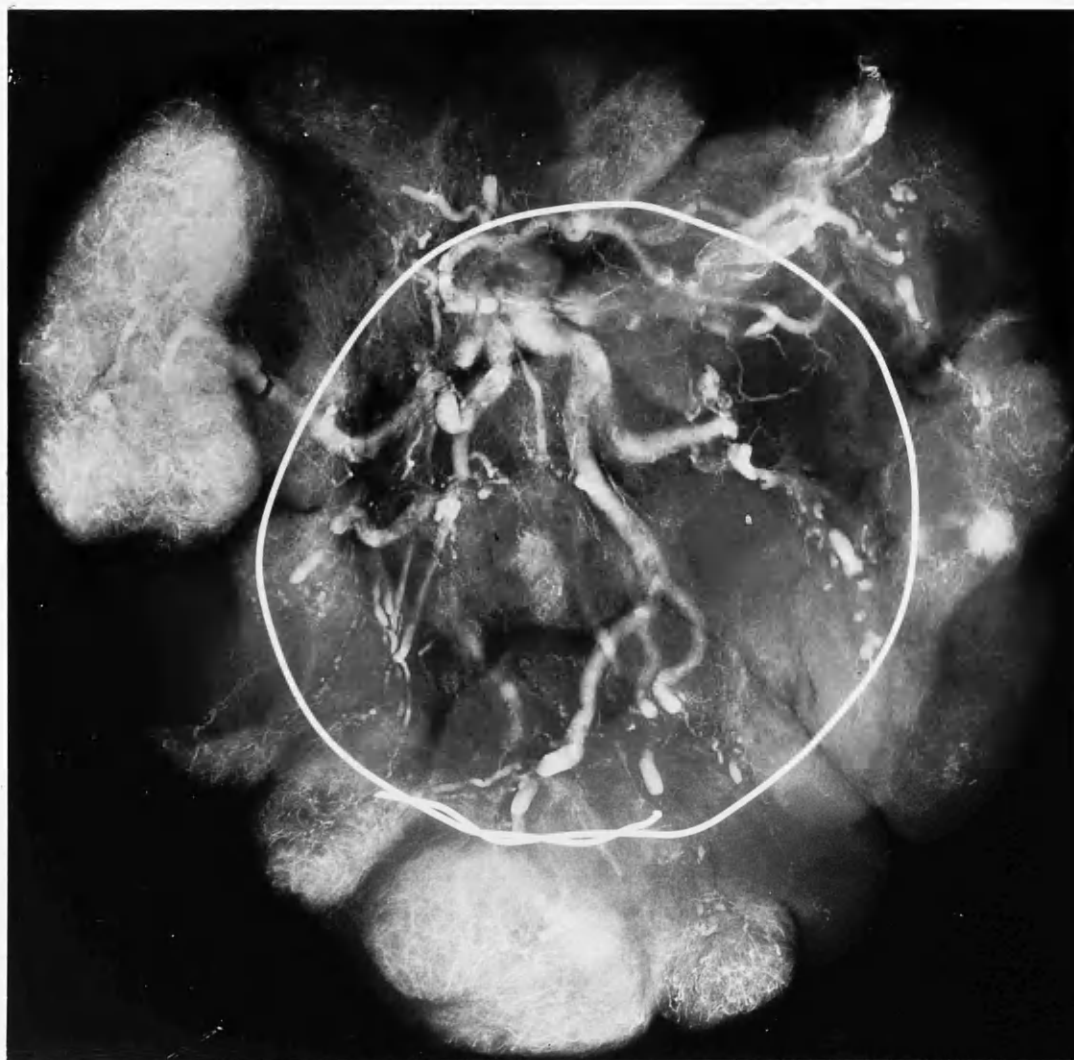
X-ray of the injected placenta extrachorialis shown in Fig. B.18. A wire was laid on the placenta at the margin of the chorionic plate and it can be seen that cotyledons situated outside this are well vascularised.
